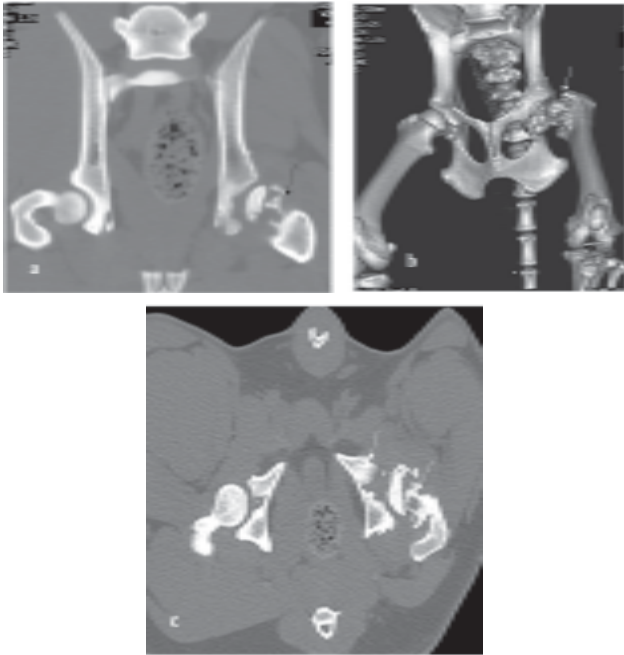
Reformatted CT image demonstrating (a) fragmentation and osteonecrosis of the femoral head in the dorsal plane (black arrow), (b) femur head flattening with loss of joint space, irregular broken displaced head (white arrow), and presence of osteophytes at the femur head and acetabulum rim in the 3D image; (c) fractured femur head with osteonecrosis and subchondral bone sclerosis with irregular acetabular margin (white arrow) and marked joint surface deformity in the transverse image.
